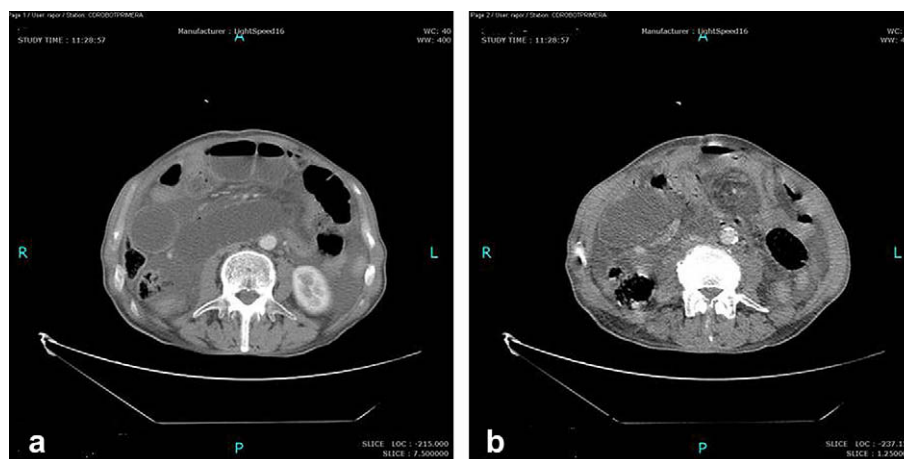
Axial contrast enhanced sequential CT images show cluster of dilated small bowel loops (a) with distorted mesenteric vessels (b) ("whirl sign").
